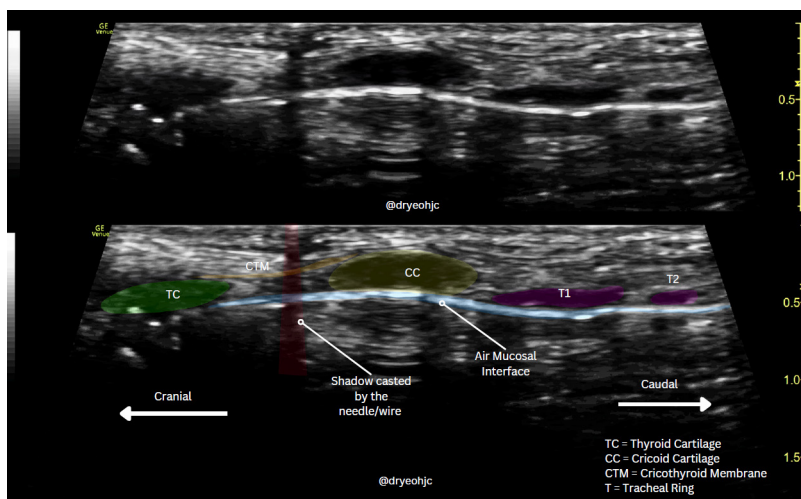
A longitudinal approach of ultrasound probe shows a needle/wire casting a shadow and used to mark the location of the cricothyroid membrane.
